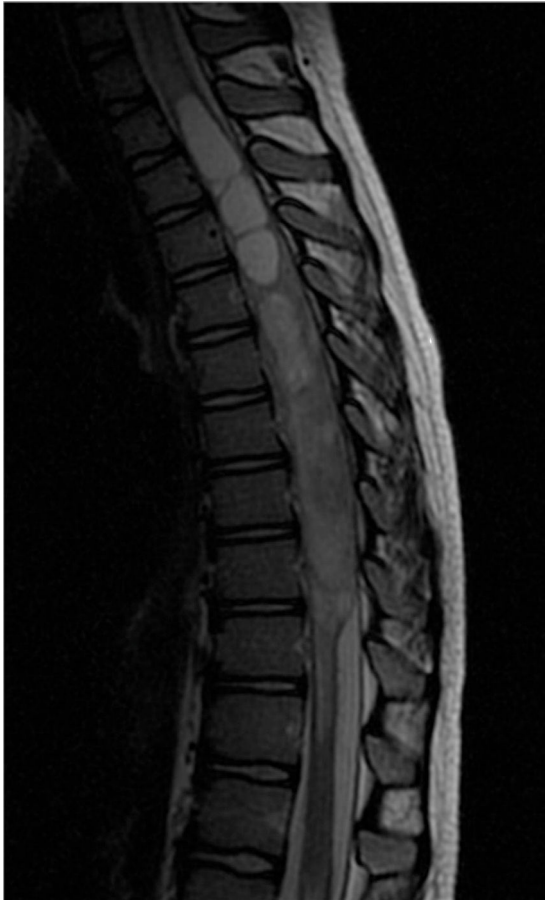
Craniomedullary magnetic resonance imaging study. Sagittal T2-weighted sequence before contrast administration showing an intramedullary tumour from D5 to D9, and syringomyelia proximal to the tumour.
